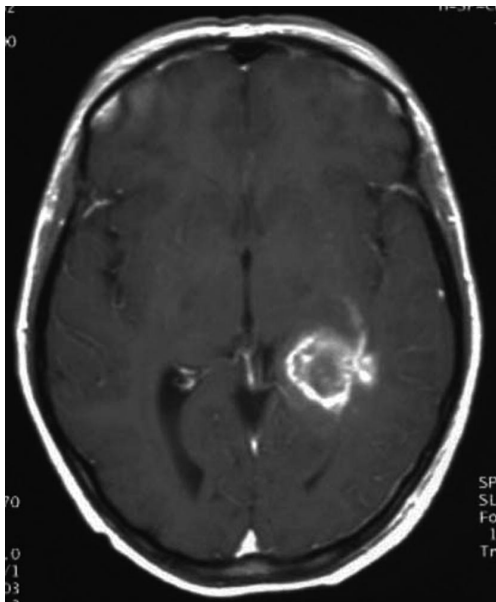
Enhanced T1-weighted magnetic resonance image of mixed density lesion, which on biopsy was shown to be a grade 4 astrocytoma.
